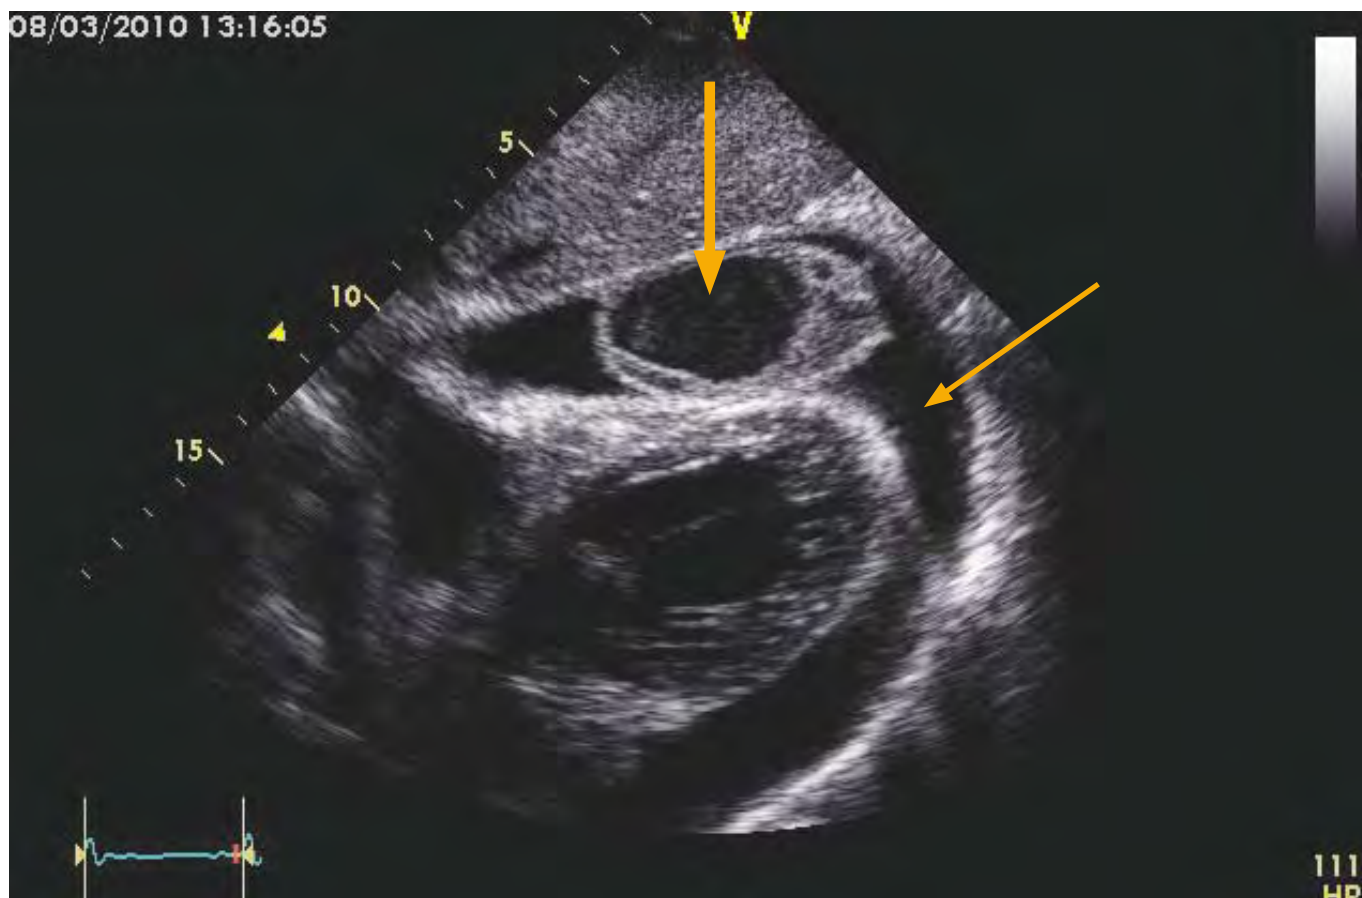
This is a subcostal echocardiography image demonstrating a circumferential pericardial effusion (arrow) with an "egg-shaped" cyst-like mass (arrow: bold) seen adjacent to the liver. The epicardium is relatively smooth without large pericardial strands visualised.
